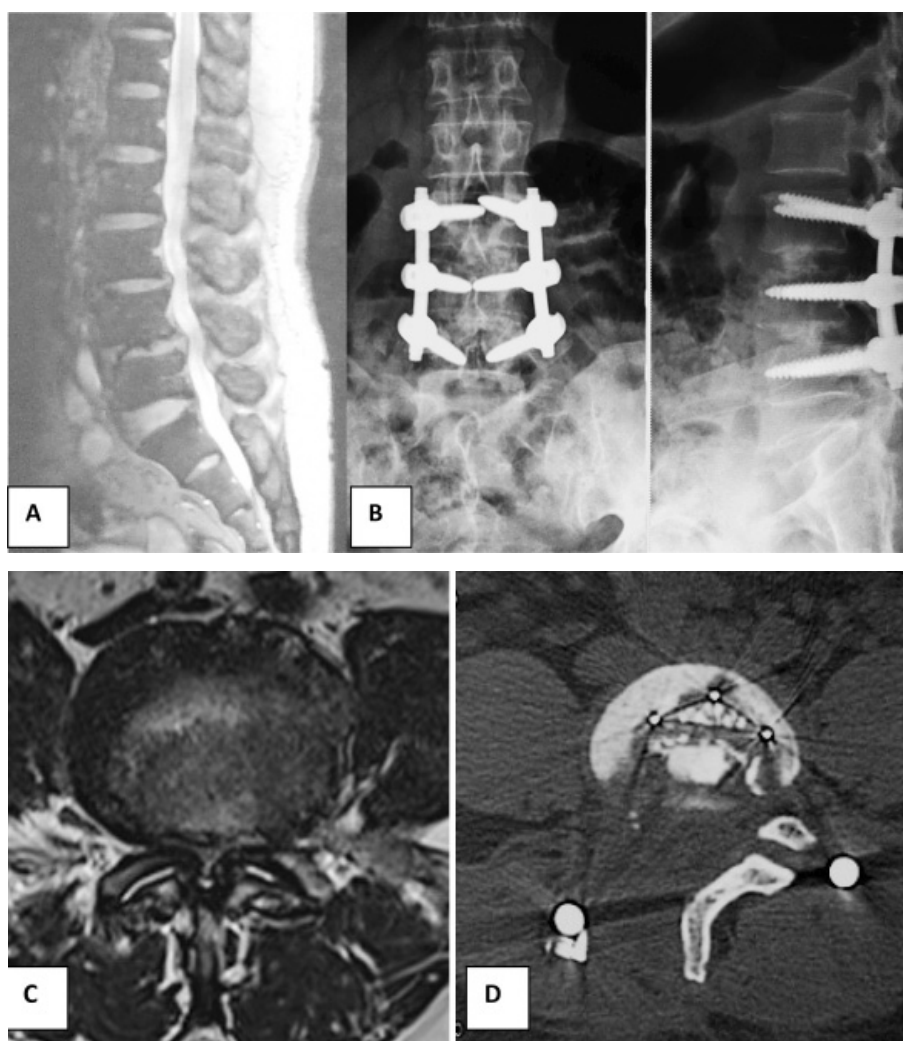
A 56-year-old female patient, Pre-op. MRI : Spondylolisthesis L3-L4, L4-L5 (A), severe spinal canal stenosis on axial view (C), 6 months after unilateral approach for bilateral decompression and fusion at L3-L5 showed no halo around screws and trabecular bone bridge at L4-L5 space on AP plain film (B). Post op Axial CT L4-5 (D)
